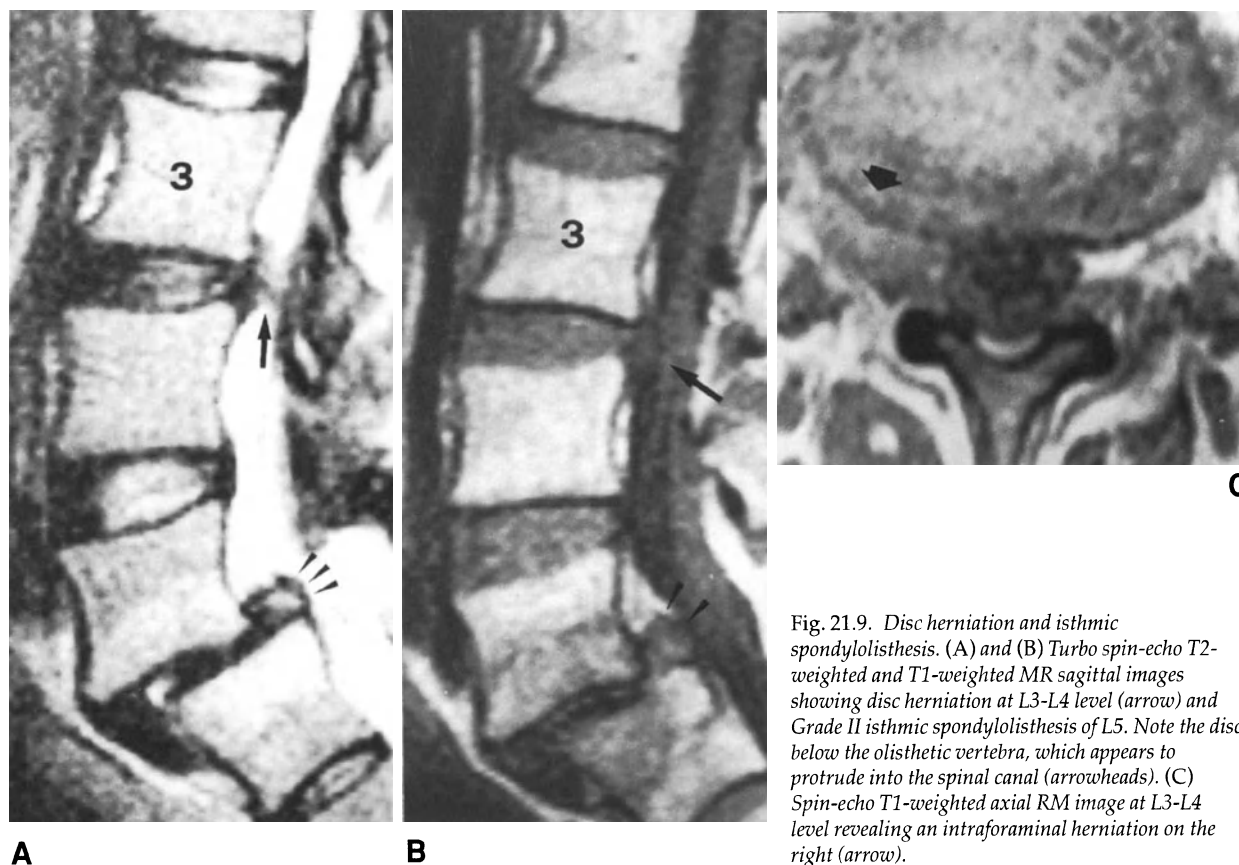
Disc herniation and isthmic spondylolisthesis. (A) and (B) Turbo spin-echo T2-weighted and T1-weighted MR sagittal images showing disc herniation at L3-L4 level (arrow) and Grade II isthmic spondylolisthesis of L5. Note the disc below the olisthetic vertebra, which appears to protrude into the spinal canal (arrowheads). (C) Spin-echo T1-weighted axial RM image at L3-L4 level revealing an intraforaminal herniation on the right (arrow).
